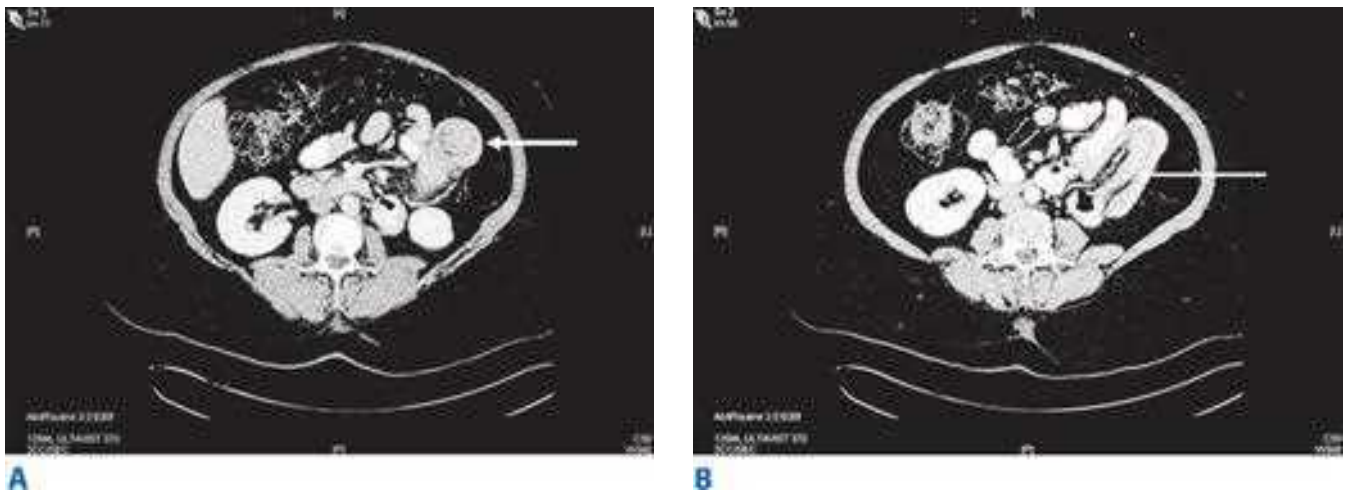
Small bowel intussusception. Panel A demonstrate the target sign seen on computed tomography scans in patients with small bowel intussusception (*arrow*). Panel B demonstrates the distal bowel clearly within the lumen of the proximal bowel (*arrow*).
